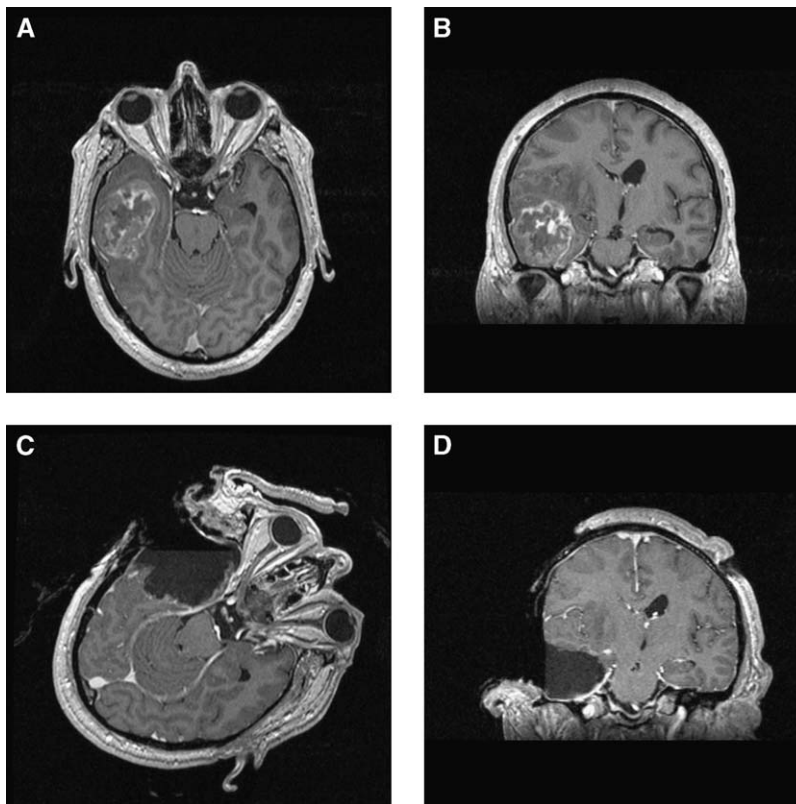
T1-weighted magnetization prepared rapid acquisition gradient echo sequence images of a right temporal World Health Organization grade IV glioblastoma in a 57-year-old man. Intraoperative imaging confirms the removal of the contrast-enhancing tumor parts (A, B: preoperative images; C, D: intraoperative images; A, C: corresponding axial slices; B, D: corresponding coronal slices).
